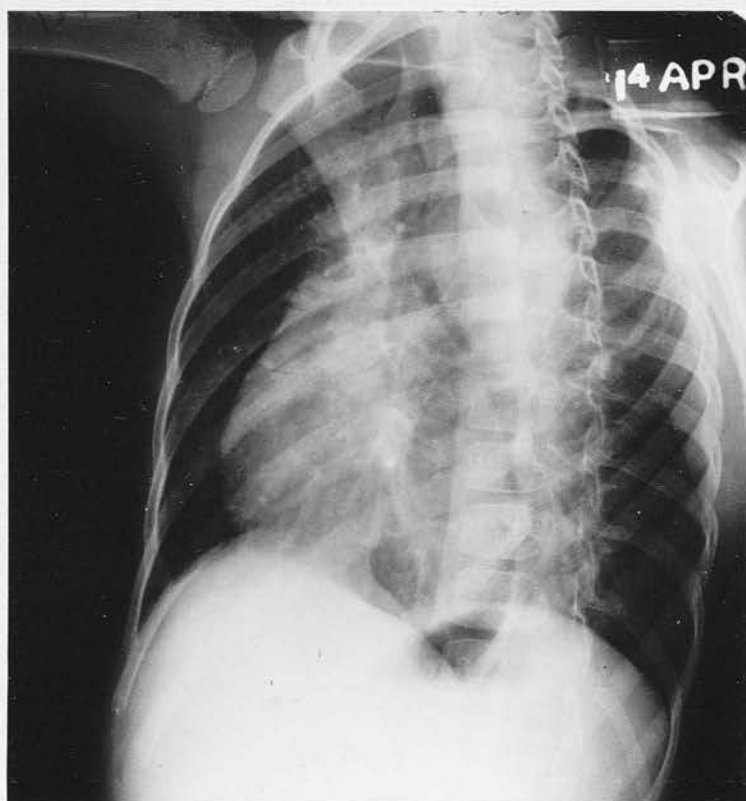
Radiograph of Case 58. Very large Ductus with marked improvement 3 weeks after ligation.
